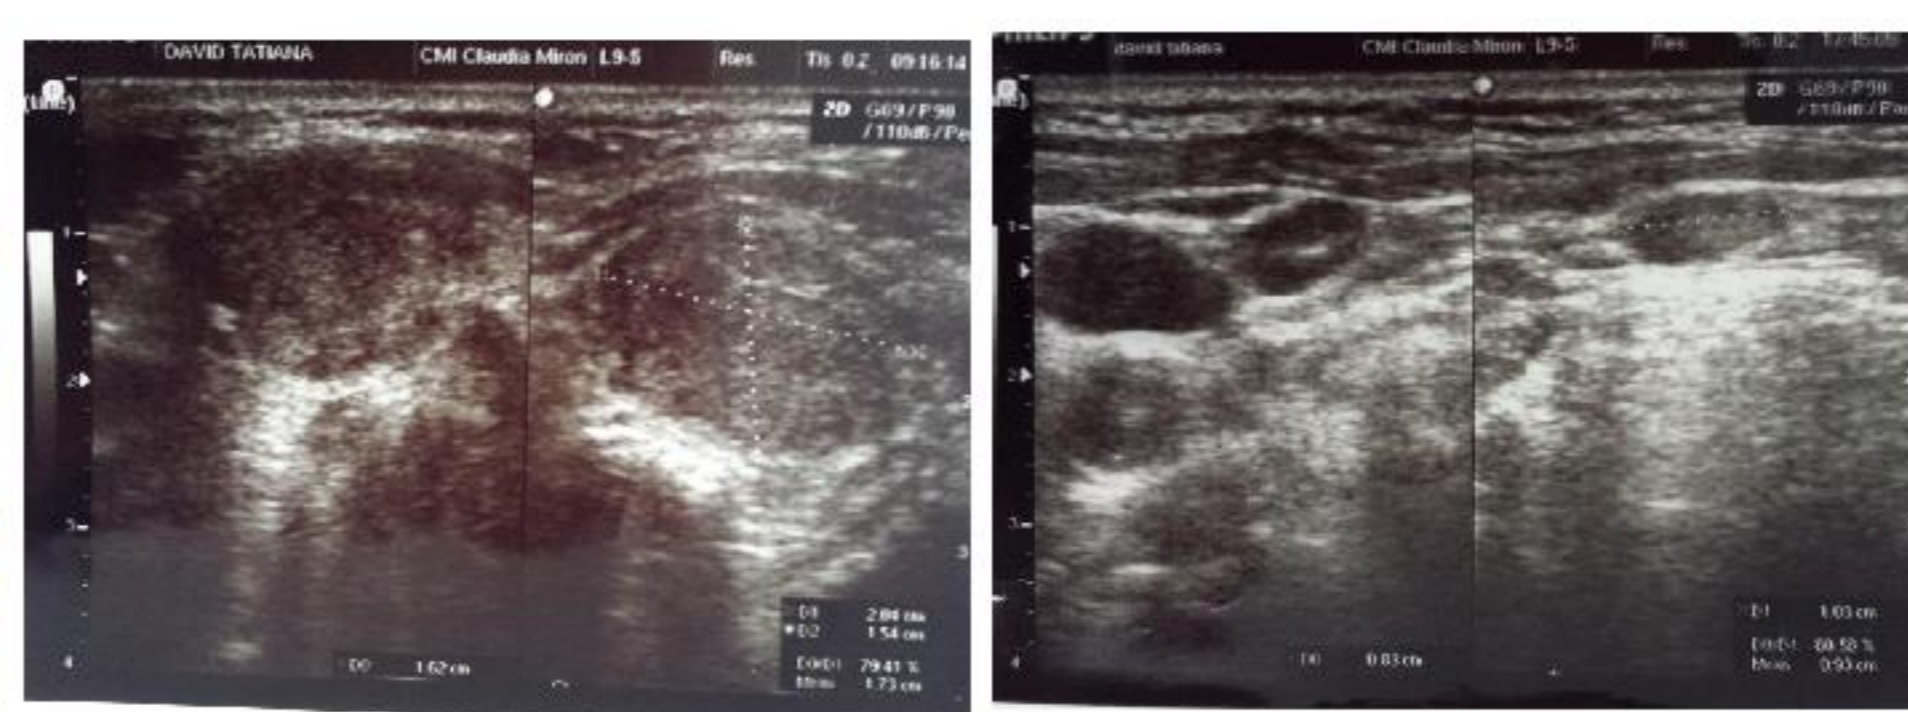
(a) Ultrasonography RTL. (b) Ultrasonography LTL.
